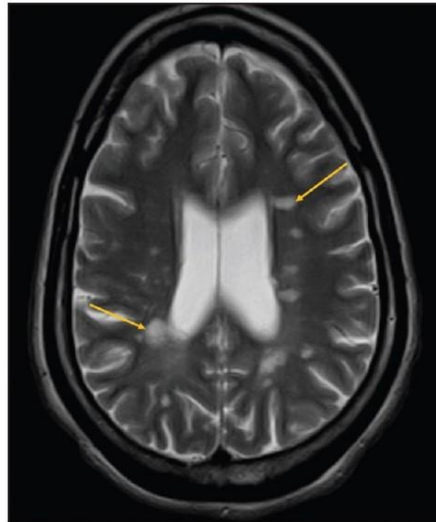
Brain MRI of an MS patient. Axial T2 image shows hyperintense lesions (yellow arrows) in the periventricular location along bilateral lateral ventricles (Katdare A and Ursekar M, 2015).
